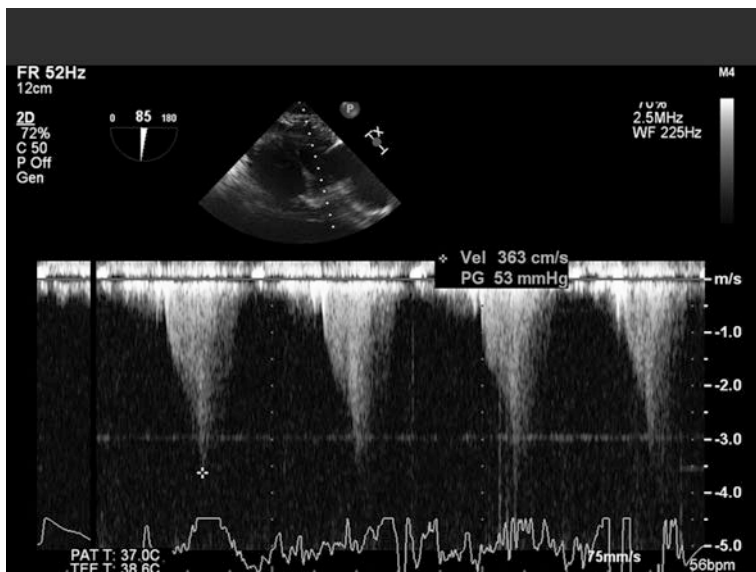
Pulse wave Doppler in the left ventricular outflow tract revealing a “dagger” shaped wave consistent with dynamic outflow obstruction
